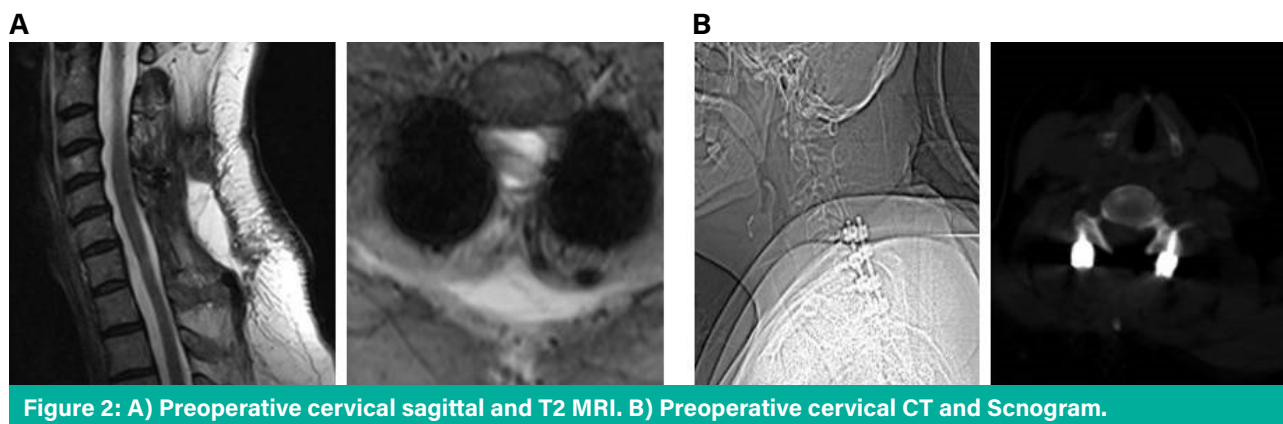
A) Preoperative cervical sagittal and T2 MRI. B) Preoperative cervical CT and Scnogram.
